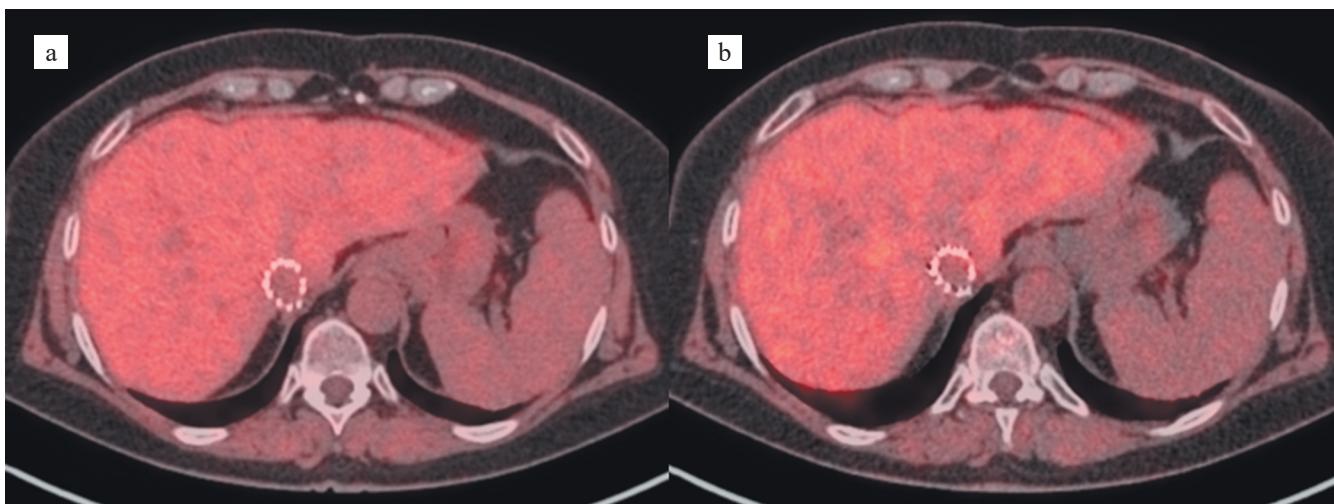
Axial fused PET/CT images with ^{18}F -FMISO (native CT): (a) at 90 minutes post-injection; (b) at 180 minutes post-injection. Diffuse tracer uptake is evident in the liver, with higher tracer retention relative to background at 180 minutes compared to 90 minutes
